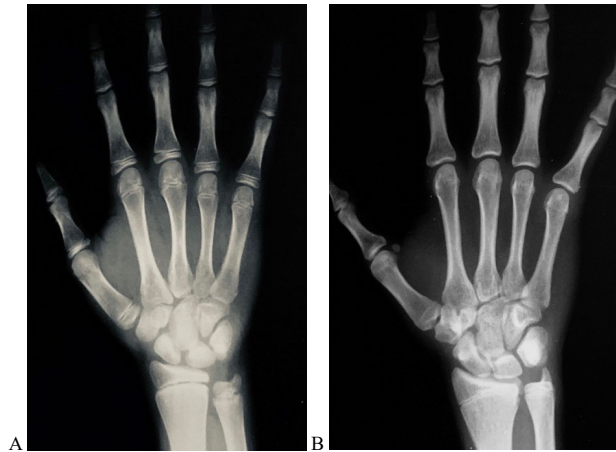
A)* X-ray film of the hand at the beginning of the puberal growth phase: the pisiform nucleus is present but quite small, the sesamoid of the thumb is not ossified, and the growth cartilages of the phalanges are well evident. *B)* X-ray taken at the end of the puberal growth: The pisiform nucleus has become very large, the sesamoid of the thumb is well apparent, and the growth cartilages of the phalanges are almost completely closed.
